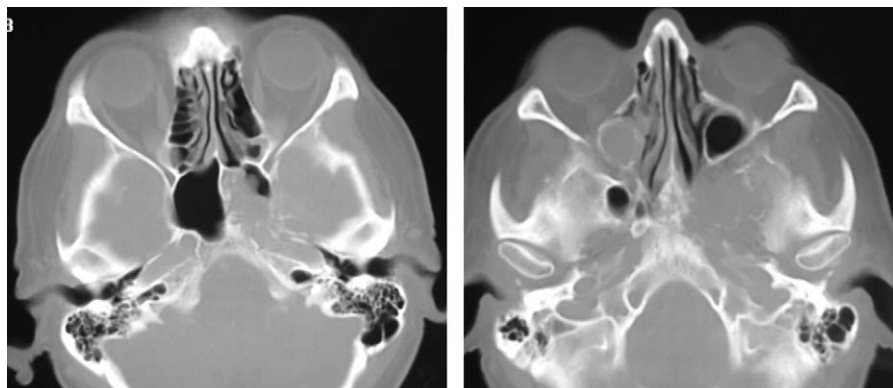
Lytic metastasis of renal origin to the left sphenoid: axial CT aspect.
